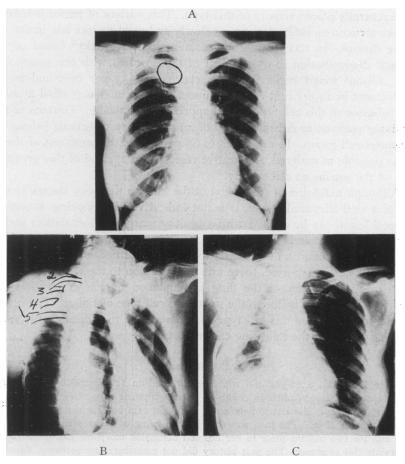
(A and B) Case 1: Routine and overexposed roentgenograms showing destruction of 3d, and 4th ribs adjacent to transverse processes.
